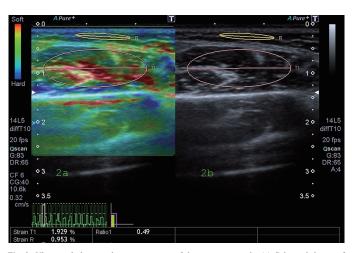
Ultrasound elastography measurements of the masseter muscle. (a) Color-coded map of the strain elastography in the region of interest ranging from red to blue. Blue areas represent harder tissues, while red areas represent softer tissues. (b) The same region of interest in B-mode ultrasonography. Upper circle selects subcutaneous fat tissue as the reference area, and lower circle includes the masseter muscle region.
